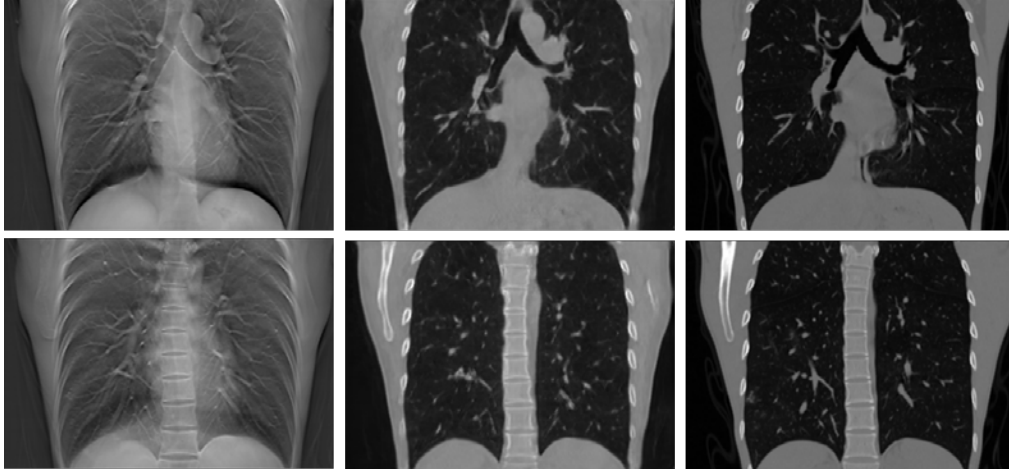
Coronal slices of: FDK-based reconstruction (left), prediction (center) and CT (right).
